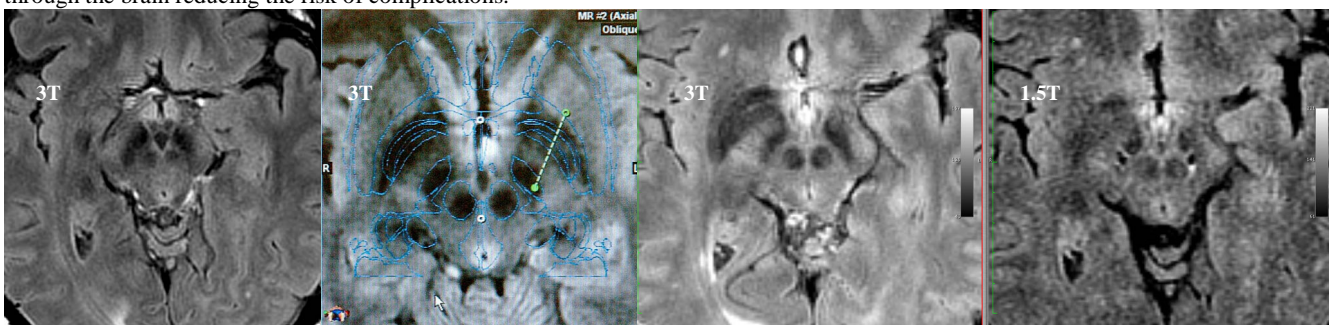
Pre-operative FLAIR imaging of the STN.
